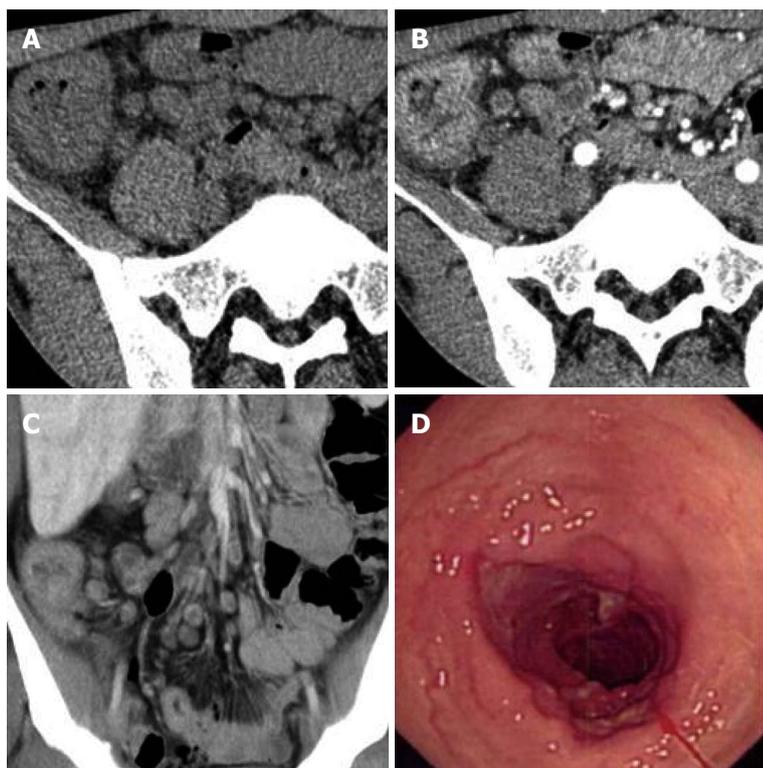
Computed tomography and endoscopic changes of intestinal tuberculosis in a 43-year-old man. A: Plain computed tomography (CT) scan showed bowel-wall thickening in the ileocecum; B: During the arterial phase, contrast-enhanced CT scan demonstrated moderate homogeneous enhancement; C: Mesenteric necrotic lymph nodes and comb sign were noted on coronal CT imaging; D: Endoscopic examination showed a ring-like ulcer in the ileocecum.
